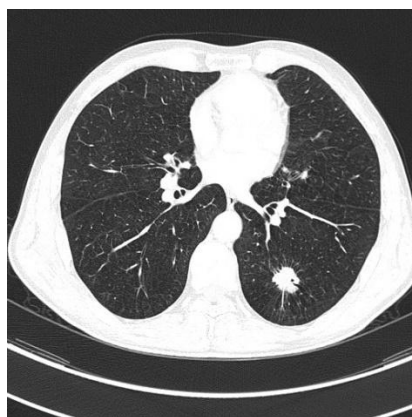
Cross section of a thoracic CT parenchymal window showing a nodule of the lower left lobe
